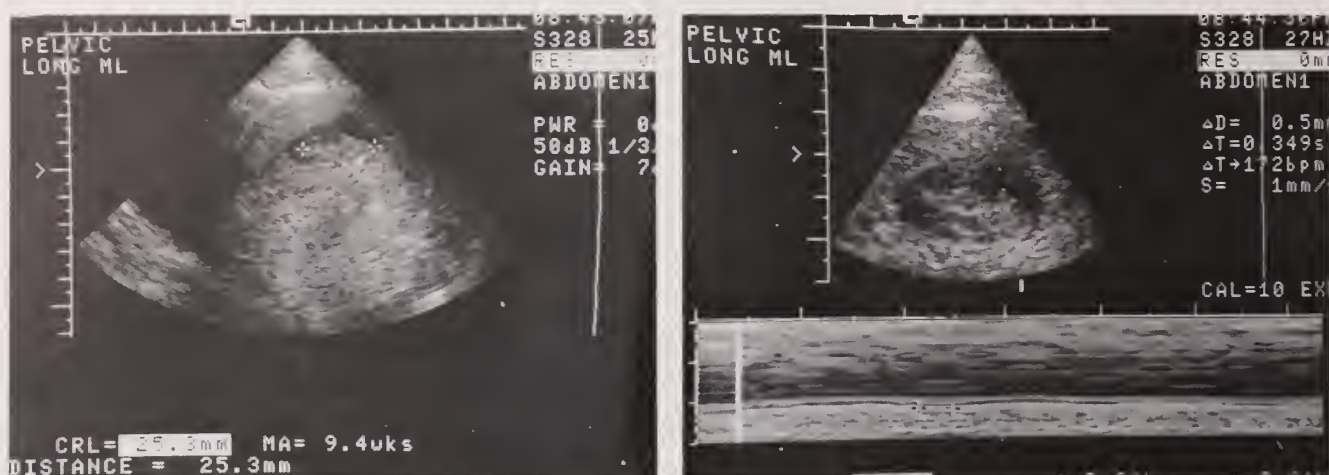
Ultrasound images of the intrauterine gestation demonstrating crown-rump length of 2.5 cm corresponding to a gestational age of 9.4 weeks (A) and cardiac activity on M-mode (B).
